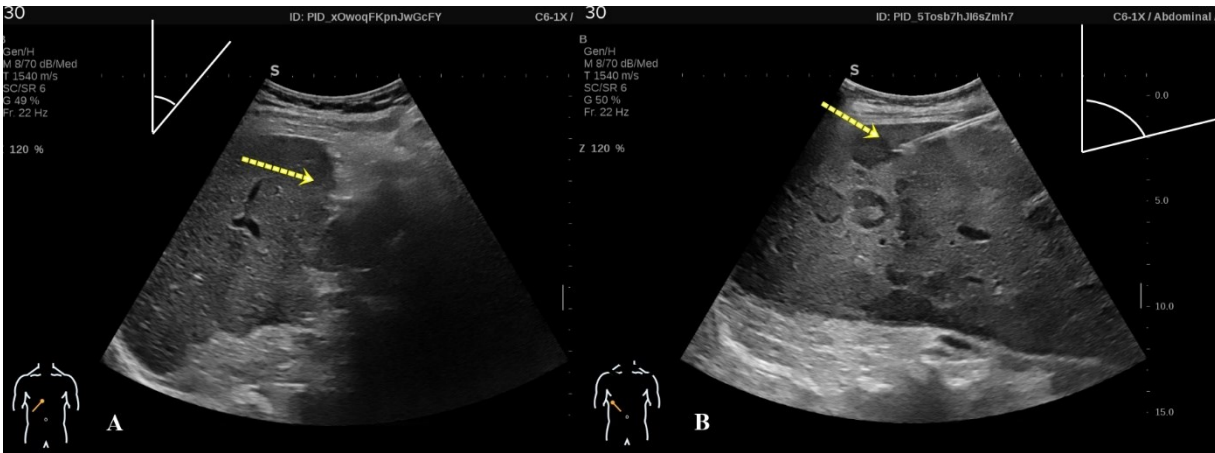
(A) Ultrasound-guided liver tumor biopsy with a narrow needle angle, resulting in poor needle visibility (yellow arrow). (B) A wider needle angle, significantly enhancing needle shaft visualization, demonstrating the direct relationship between needle angle and visibility under ultrasound.
